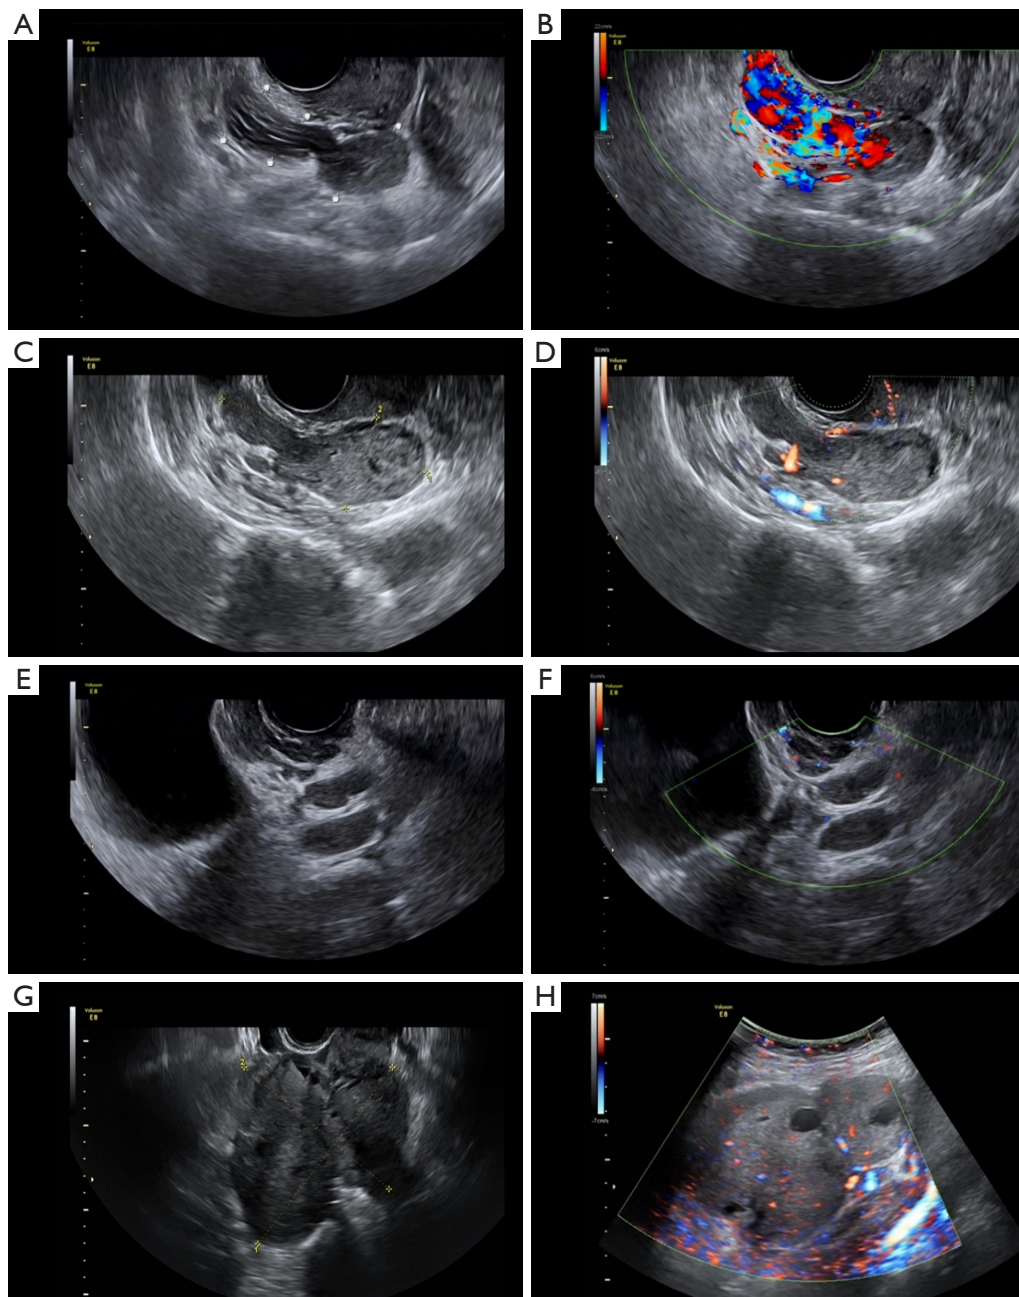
Transvaginal ultrasound and color Doppler ultrasound findings of IVL. (A) A cord-like hypoechoic mass approximately 6.2 cm in length was observed adjacent to the right side of the uterus. Multiple hyperechoic lines were seen within the hypoechoic area. (B) CDFI showed abundant blood flow signals within the mass. (C) A cord-like hypoechoic mass approximately 6.3 cm in length was observed adjacent to the right side of the uterus. (D) CDFI showed poor blood flow signals within the mass. (E) Multiple hypoechoic masses adjacent to the uterus were observed, presenting as beaded structures. One of the masses had a long axis diameter of approximately 3.6 cm. (F) CDFI showed poor blood flow signals within the mass. (G) A solid hypoechoic mass adjacent to the right side of the uterus was observed, approximately 13.6 cm in length. It exhibited a solid mass morphology resembling lobulated shapes, with small cystic areas visible internally. (H) CDFI showed poor blood flow signals within the mass. CDFI, color Doppler flow imaging; IVL, intravenous leiomyomatosis.
